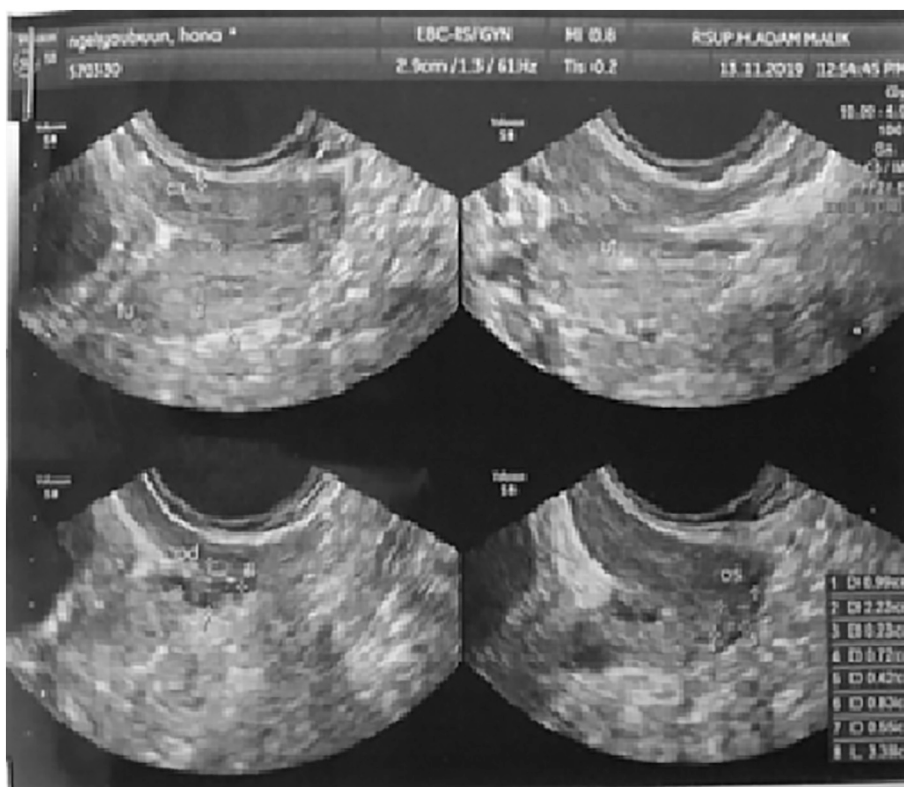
Ultrasound Evaluation.
